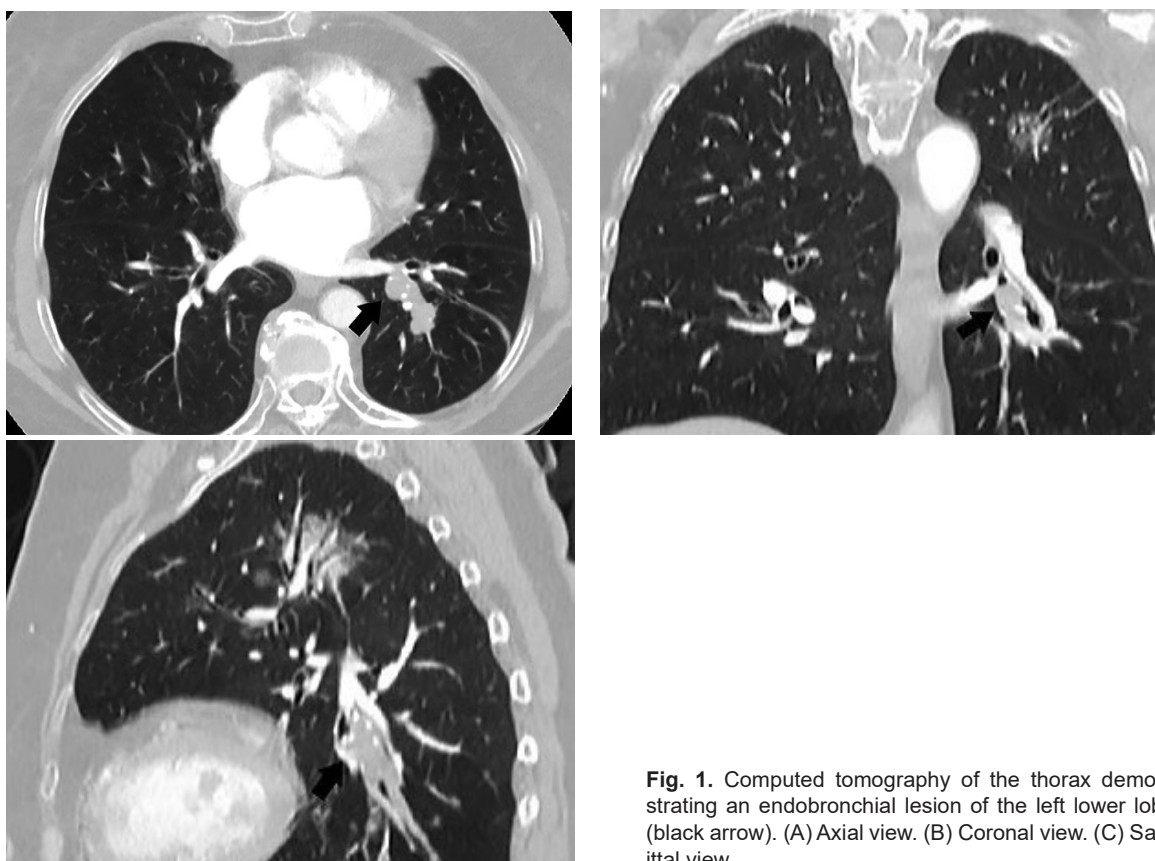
Computed tomography of the thorax demonstrating an endobronchial lesion of the left lower lobe (black arrow). (A) Axial view. (B) Coronal view. (C) Sagittal view
